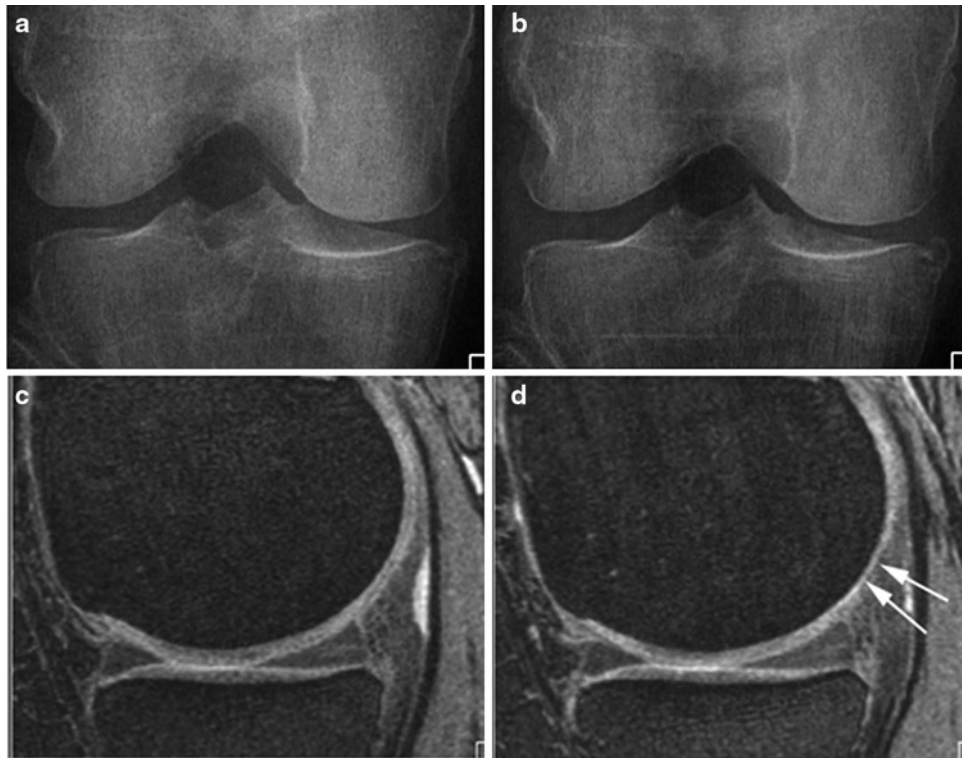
Progressive MRI-detected cartilage loss. Baseline (a, c) and 24-months follow-up examinations (b, d). No radiographic progression is seen (a, b). On sagittal DESS MRI, progressive cartilage loss in the posterior medial femur is observed at follow-up (*arrows, c, d*)
